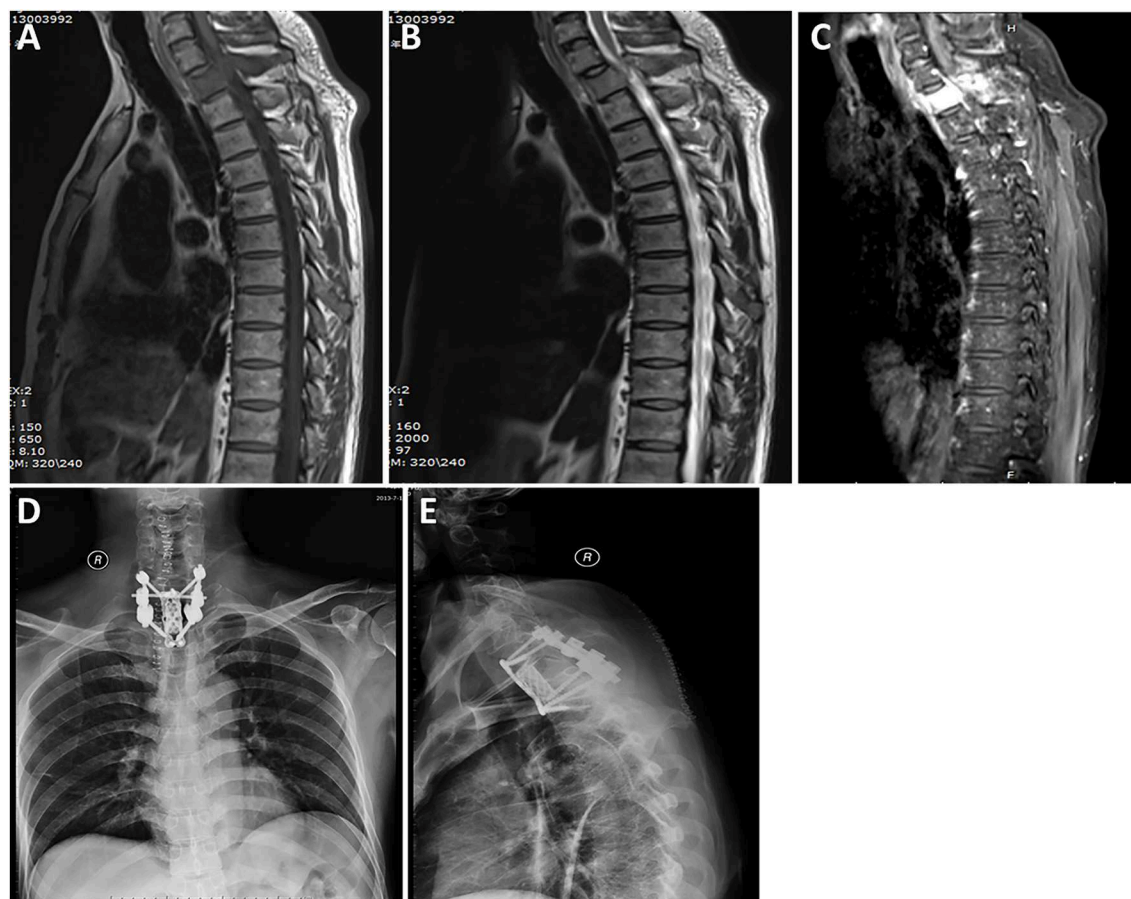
A case labeled as vertebral type because the maximal diameter of the tumor was located in the vertebral body and accessory. Preoperative T1-weighted (A) and T2-weighted (B) images revealed a tumor at the T1 level. Contrast-enhanced sagittal (C) image revealed that the tumor showed significant homogeneous enhancement. Postoperative radiograph of the thoracic spine after surgery showing that the reconstructed thoracic spine was well-maintained. Anterior-posterior view (D). Lateral view (E).
